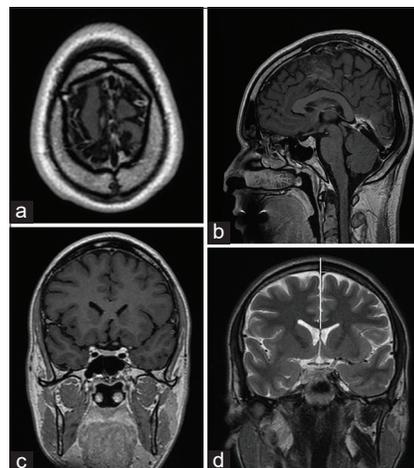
Example of location in (a) axial, sagittal (b), and coronal (c) plane of magnetic resonance image and measurement at bregma in coronal magnetic resonance image in T2 sequence (d). Vertical white line is placed at the sagittal midline. Distance from the sagittal midline to the right and left edge of superior sagittal sinus. This image shows the displacement of the superior sagittal sinus toward the left at bregma. The bregma is the hypointense gap at the top of the head (d).
